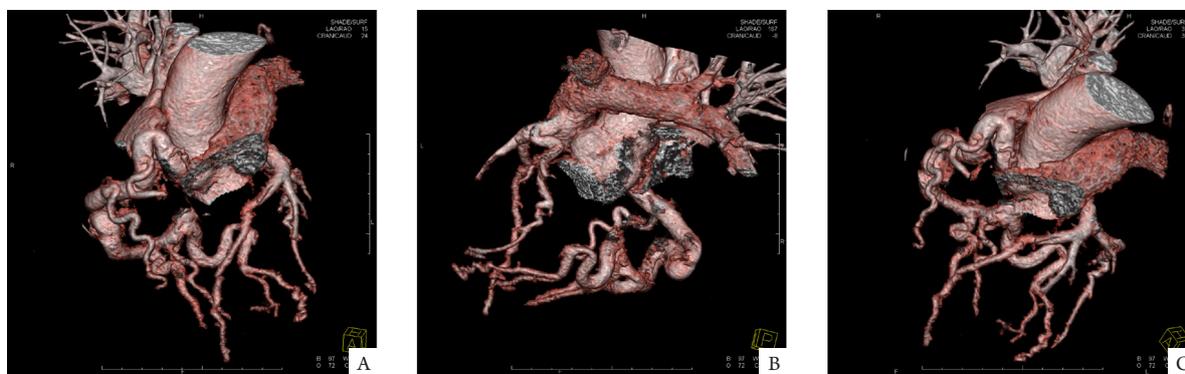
Preoperative heart computed tomography angiogram
